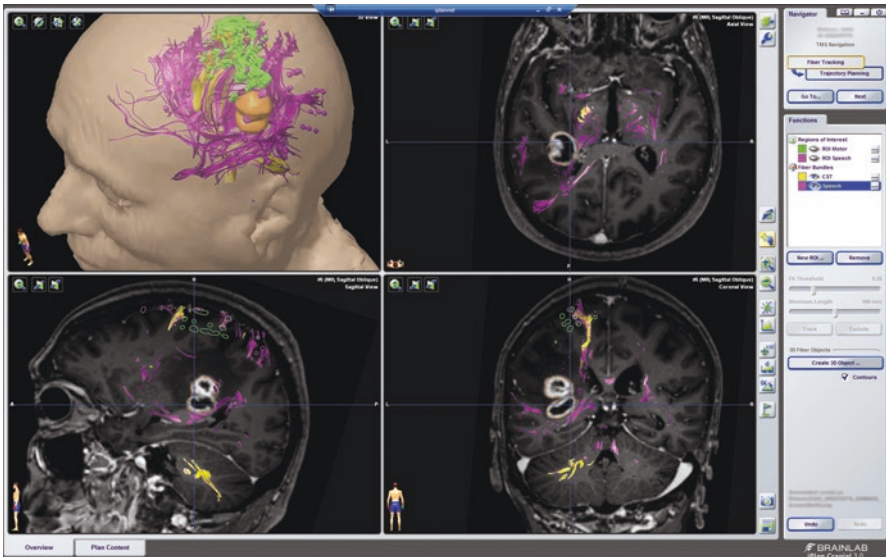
Planning within the surgical neuronavigation system. The datasets containing nTMS spots can be implemented into surgical neuronavigation systems for preoperative resection planning, intraoperative guidance, and nTMS-based tractography (here: Brainlab iPlan Net®). The motor-positive nTMS spots are visualized in *green*, and the CST, delineated by nTMS-based tractography, is shown in *yellow*. Furthermore, language-positive nTMS spots and subcortical language-related pathways are displayed in *pink*. The tractography results are visualized within the MRI sequence the nTMS mapping was conducted with. The tumor volume is shown in *orange*
